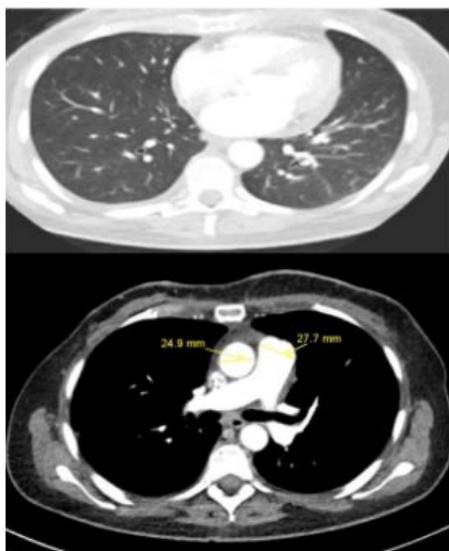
Thoracic CT negative for pulmonary embolism or active infection. Enlargement of the main pulmonary artery (27.7mm) compared to aorta (24.9mm) diameter suggesting pulmonary arterial hypertension.
